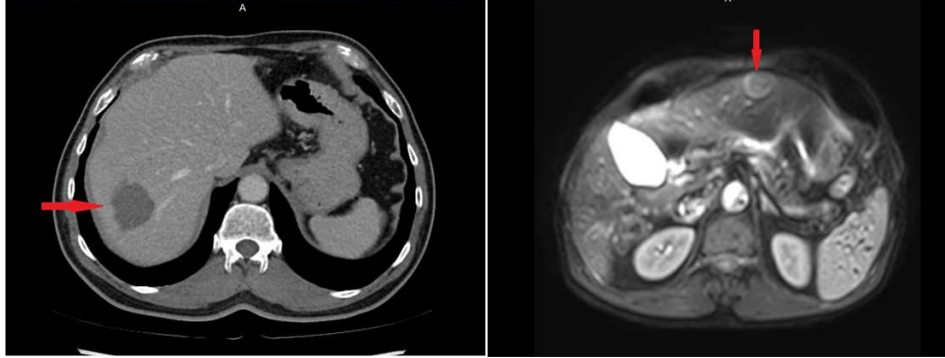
A contrast enhanced CT image - portal venous phase of the liver with a tumor (left) and a large tumor in the liver in a contrast enhanced MRI image (right).
